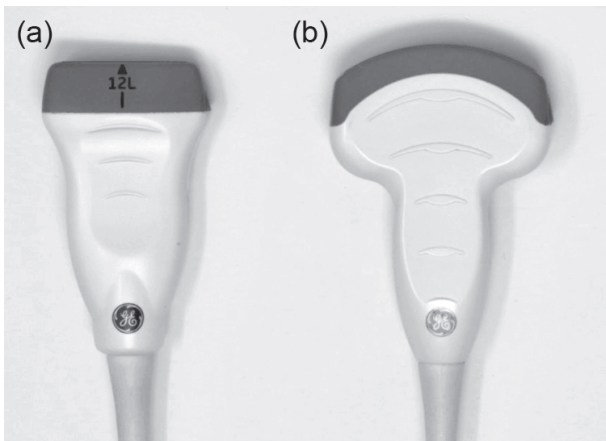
(a) Linear and (b) curvilinear ultrasound probes.
